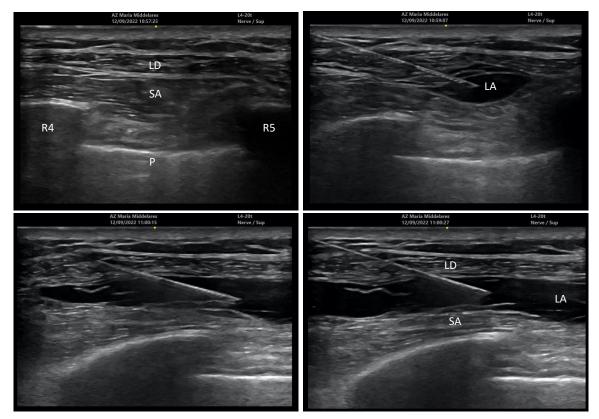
Ultrasound image with anatomy and local anaesthetic spread of superficial serratus anterior plane block. LD, Lattisimus dorsi muscle; SA, Serratus anterior muscle; R4, Rib 4; R5, Rib 5; P, Pleura; LA, Local anaesthetic.
